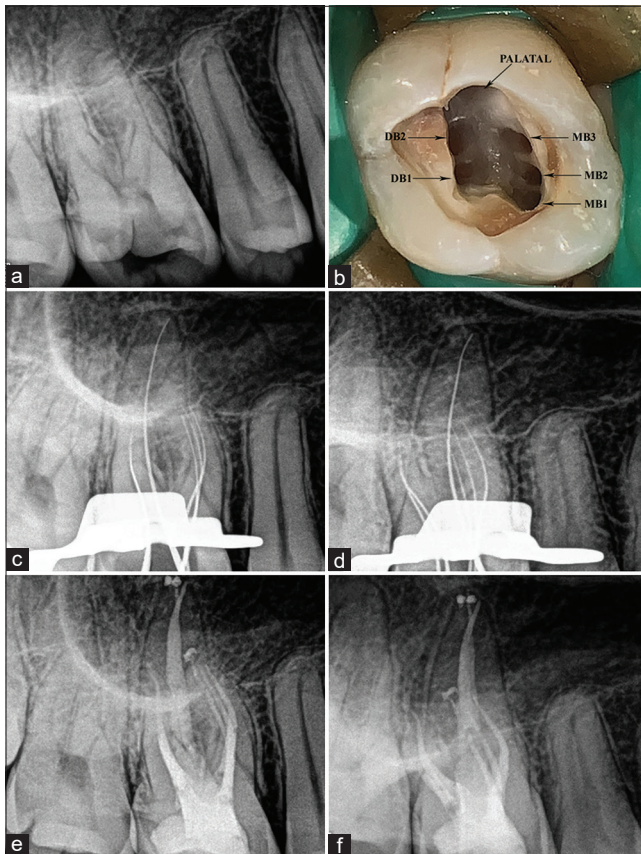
(a) Preoperative radiograph of tooth #3. (b) Access cavity showing six root canal orifices. (c and d) Angulated radiographs to confirm the working length. (e and f) Postoperative radiographs. DB: Distobuccal, MB: Mesiobuccal
